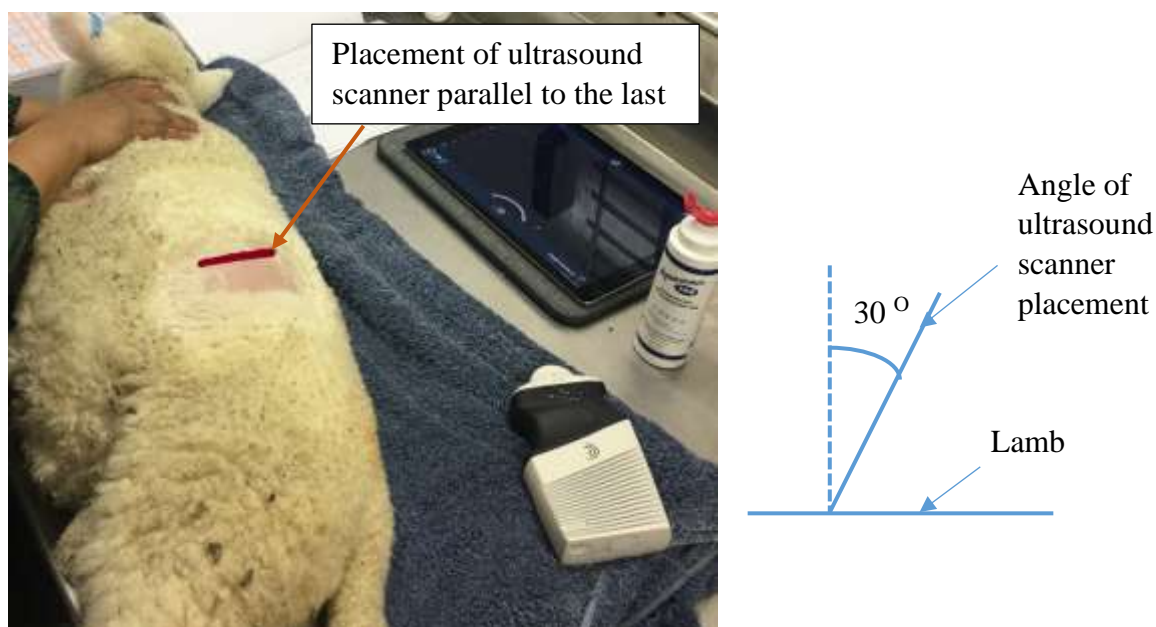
The angle and site of positioning of ultrasound scanner to capture rumen images.
